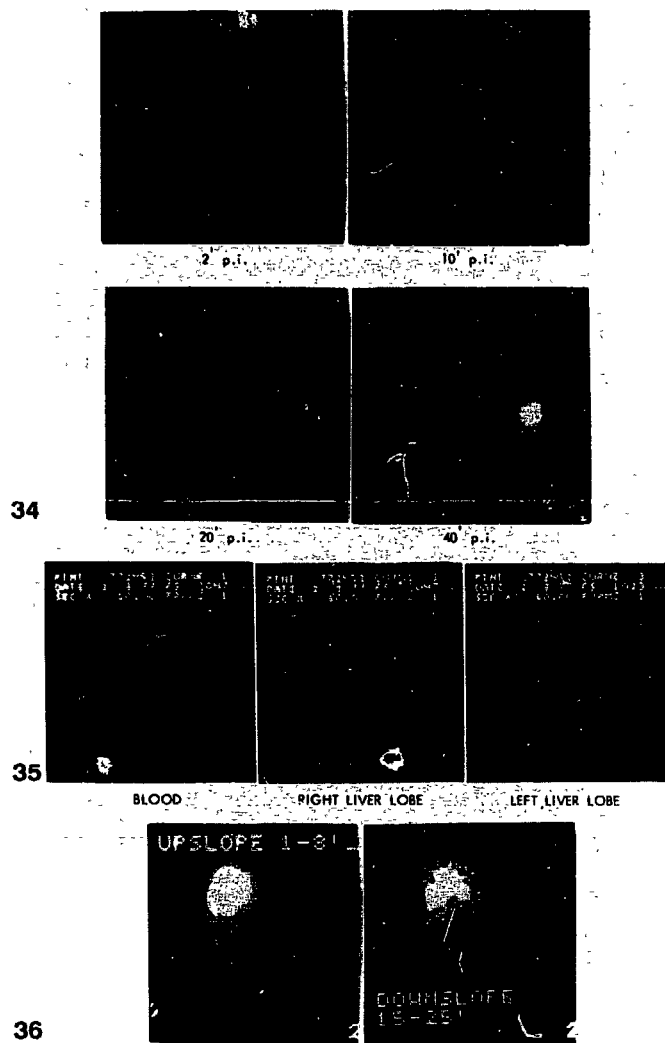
34-36 Cholescintigraphy in a patient with alcoholic hepatitis; after clinical improvement.
